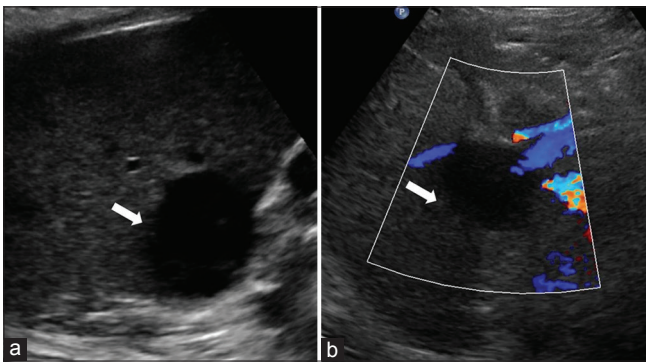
Ultrasound images (axial view) of the liver showing a segment VI liver abscess (bold white arrows) with minimal solid components within
